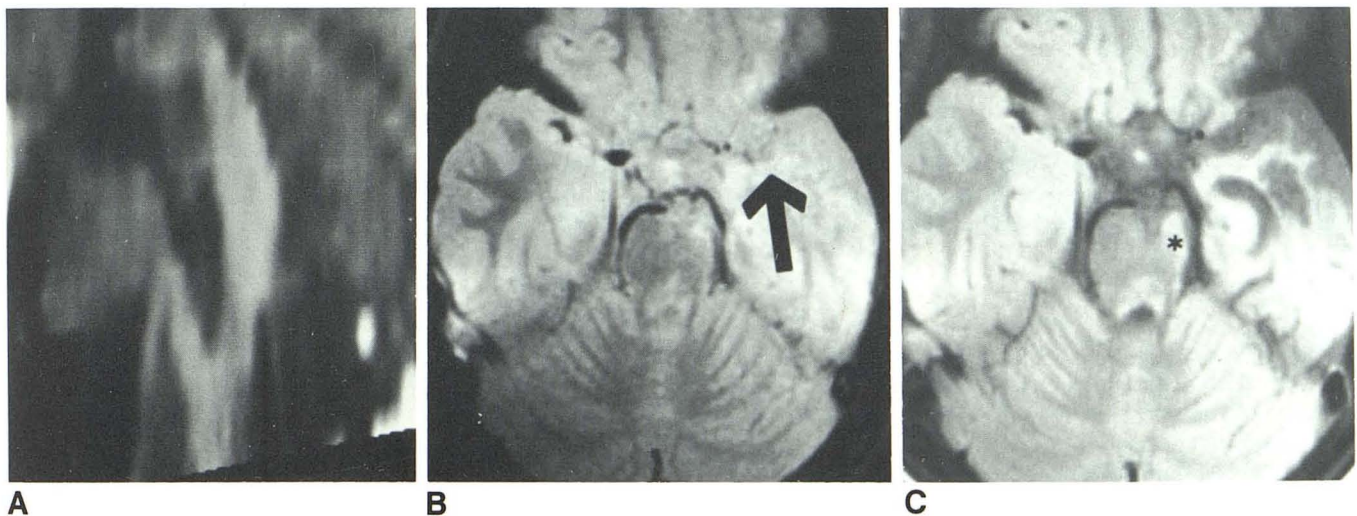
Case 3. A, Reformatted CT-enhanced image of left side of neck showing normal carotid artery bifurcation. B, Transaxial MR shows complete occlusion of left internal and middle cerebral arteries (arrow) instead of normal low signal of terminal carotid small vessels. This may represent collateral
